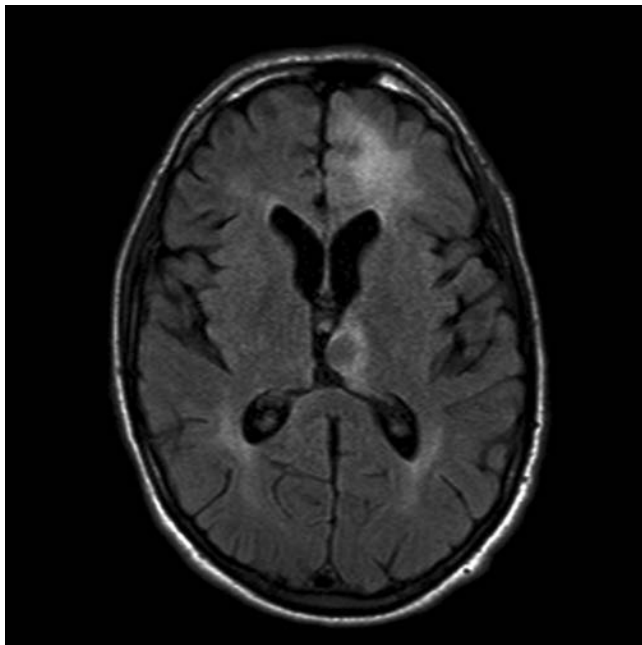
Primary CNS lymphoma. This FLAIR sequence MRI demonstrates a small periventricular mass lesion in the left thalamus. The lesion displays a signal intensity that is isointense compared with normal gray matter structures. This feature is consistent with a highly cellular lesion, a finding that suggests lymphoma but is not specific for that diagnosis. In addition, there are multiple areas of high signal intensity with ill-defined borders, most pronounced in the left frontal region. This appearance is also nonspecific, reflecting increased water content or decreased myelin in those regions, as may occur with any cause of inflammation. It is consistent with a multifocal, widely infiltrative process, and supportive of the diagnosis of lymphoma. Description provided by Dr. Paul Moots, Vanderbilt University, Nashville, TN.
